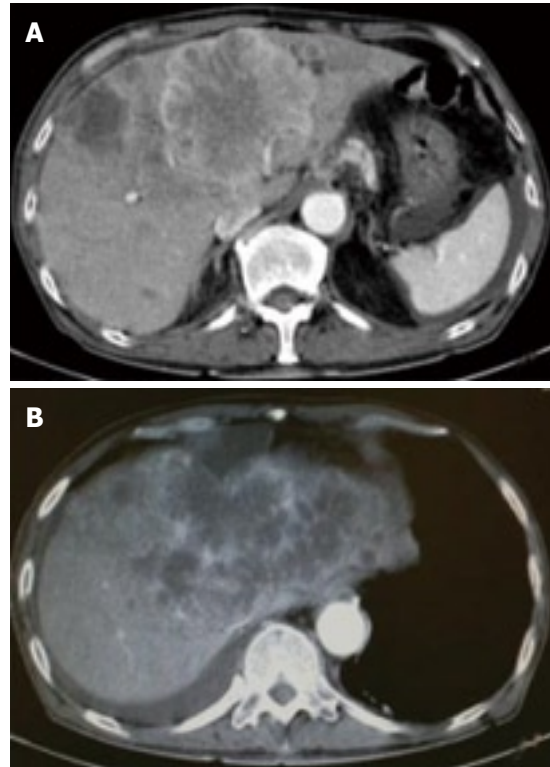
Contrast-enhanced (CE) computed tomography of the abdomen revealed a huge tumor, measuring 11 cm in diameter, which presented with ring enhancement in the arterial phase and central necrosis. A: In the medial segment; B: Multiple small-sized tumors mainly located in the anterior and medial segments of the liver.
